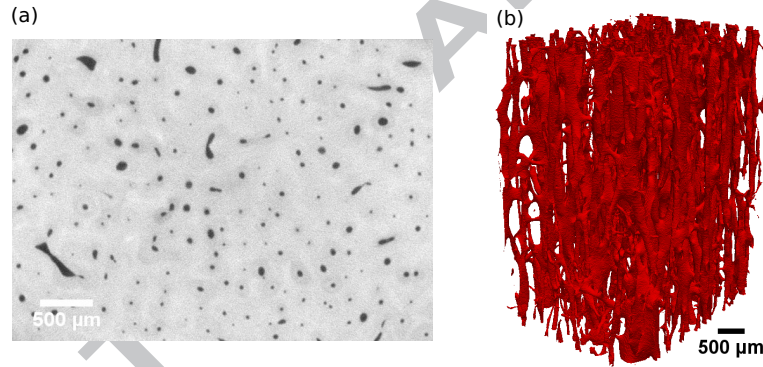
(a) One transverse gray-levels cross-section of cortical bone scanned by SR- μ CT showing the distribution of pores and mineral. (b) 3-D rendering of the pore network after binarization of the volume.
